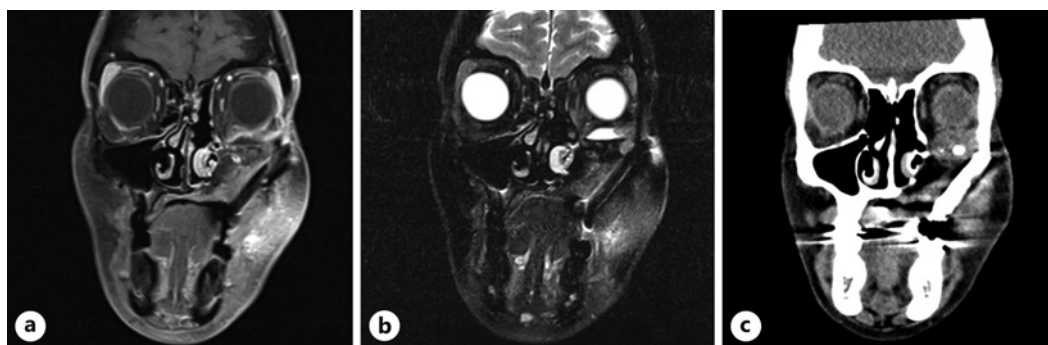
Imaging at time of recurrence. T1 (a) and T2 (b) MRI orbits with and without contrast demonstrating enhancement along the left orbital floor and superolateral maxillary sinus reconstruction bed. There is superior displacement of the inferior rectus, left frontal sinus opacification, and no proptosis. c CT maxillofacial demonstrating slight interval increase in soft tissue along the left orbital floor in the postsurgical bed, corresponding to a new area of signal abnormality on MRI.
